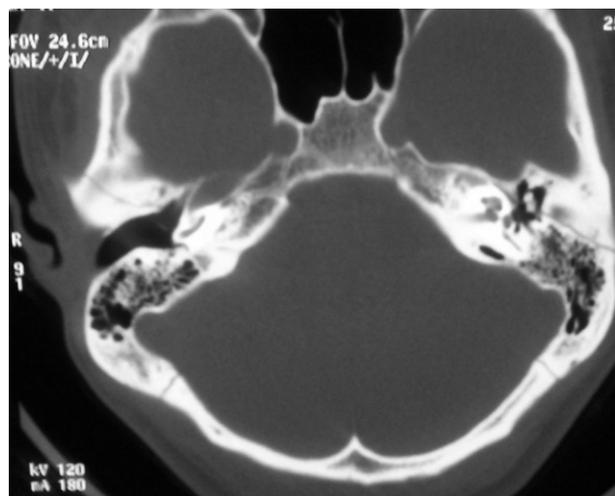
CT temporal bones showing bilateral fractures.
